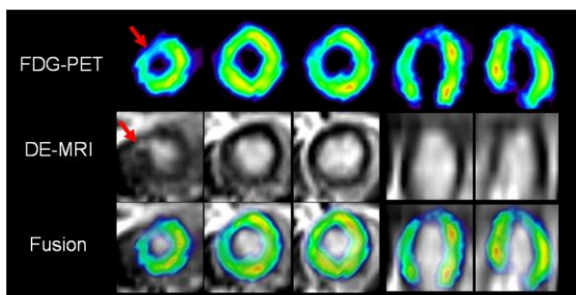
Short-axis images from apex (left) to base (right) and long-axis images. FDG PET shows an uptake defect, and DE-MRI demonstrates hyperenhanced area (red arrows).
